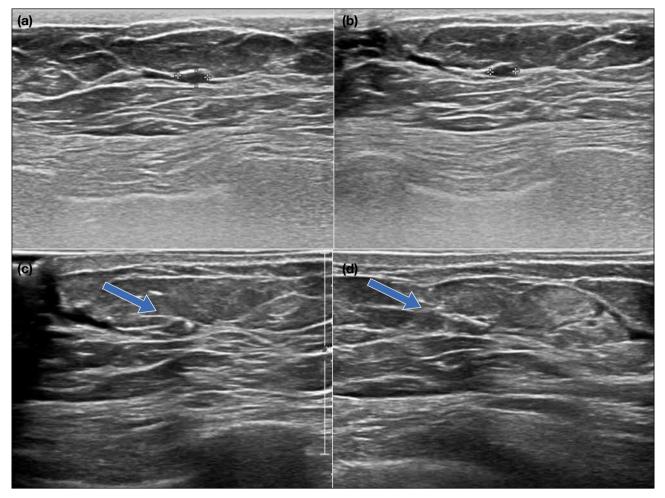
Case 1. An 86-year-old woman with previous right modified mastectomy for invasive ductal carcinoma. (a) Transverse and (b) longitudinal ultrasound views of a 4-x 2-x 4-mm circumscribed oval parallel lesion in the subareolar region of the left breast. (c) Transverse and (d) longitudinal ultrasound images confirm Magseed in situ (arrows) after ultrasound-guided placement.
